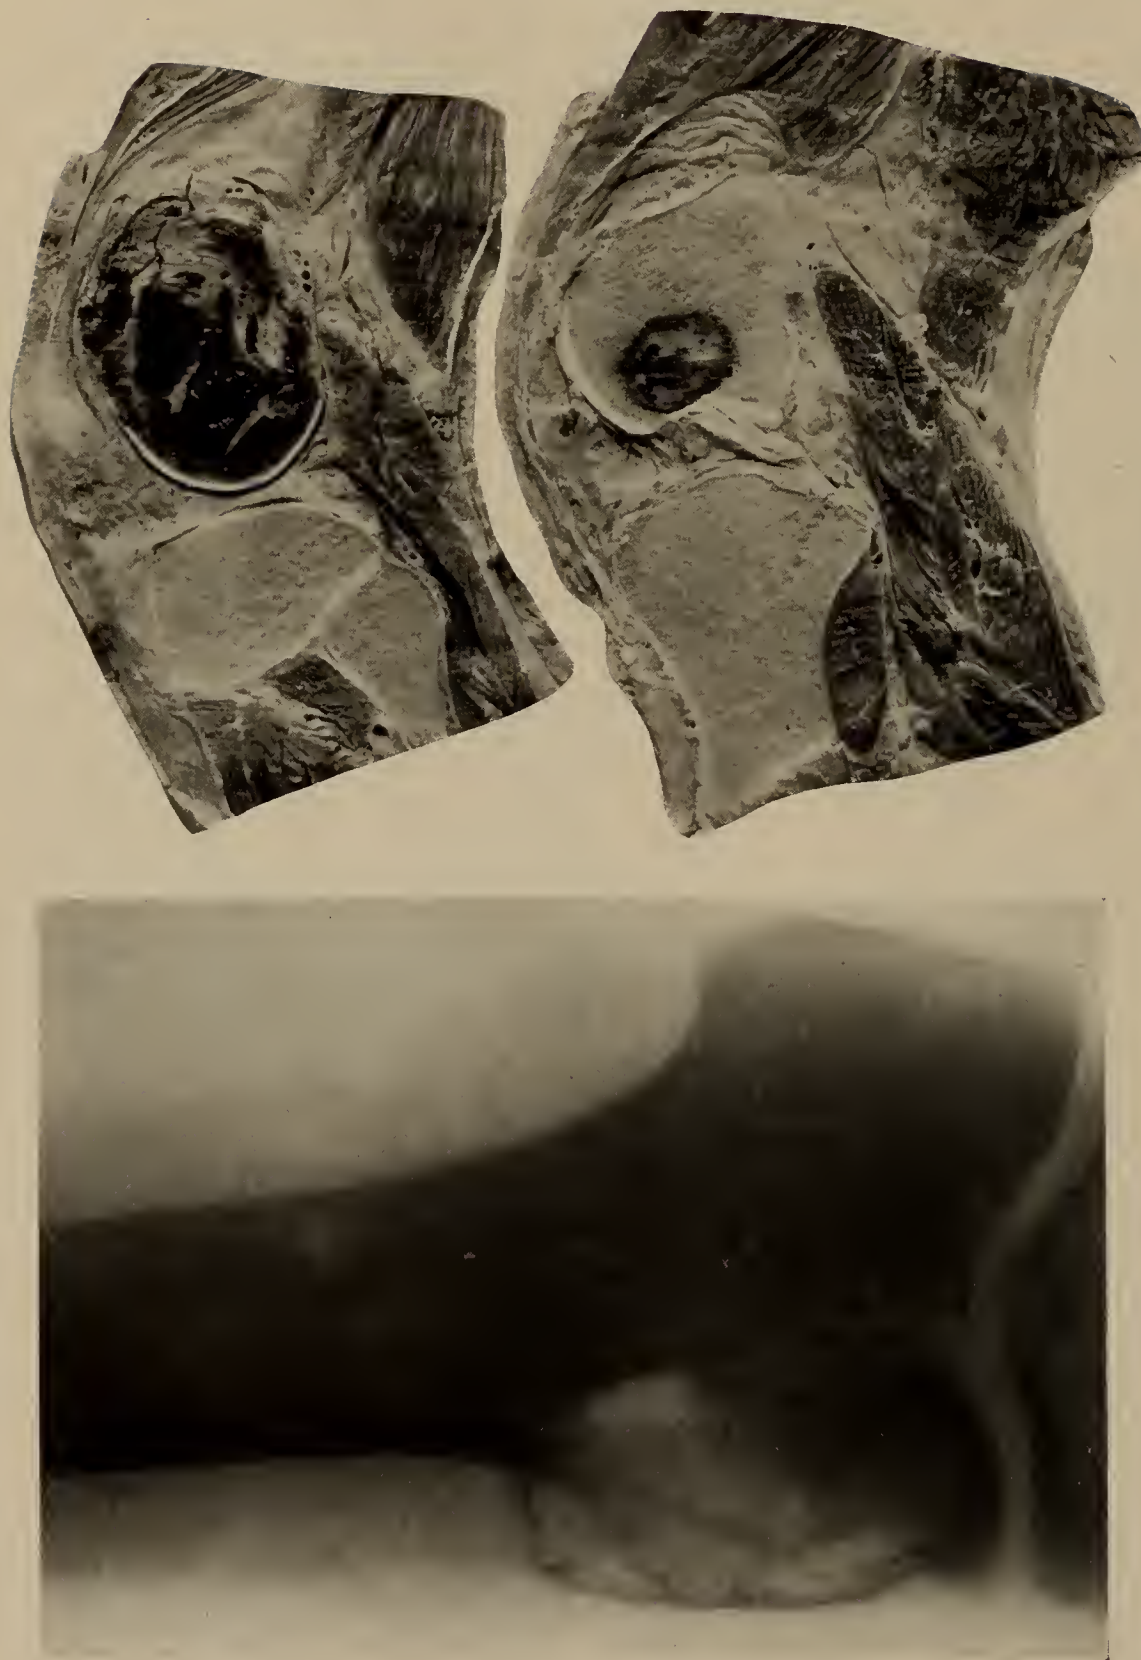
Case 580. Giant cell tumor. The roentgenogram was taken before amputation. The extent of involvement in giant cell tumor is always greater than it appears from the roentgenogram. The apparent limitation of the tumor to the external condyle is misleading as is seen from the photographs. Above, right, section through the external condyle; it shows the intact articular cartilage, while the entire condyle is displaced by the lesion. Below, right, section through the internal condyle.
